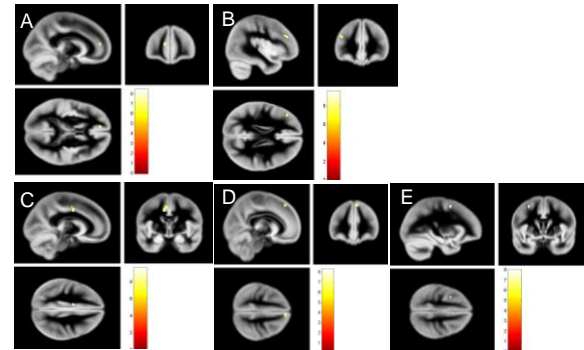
Gray matter atrophy in relapsing-remitting multiple sclerosis patients by MRI.
